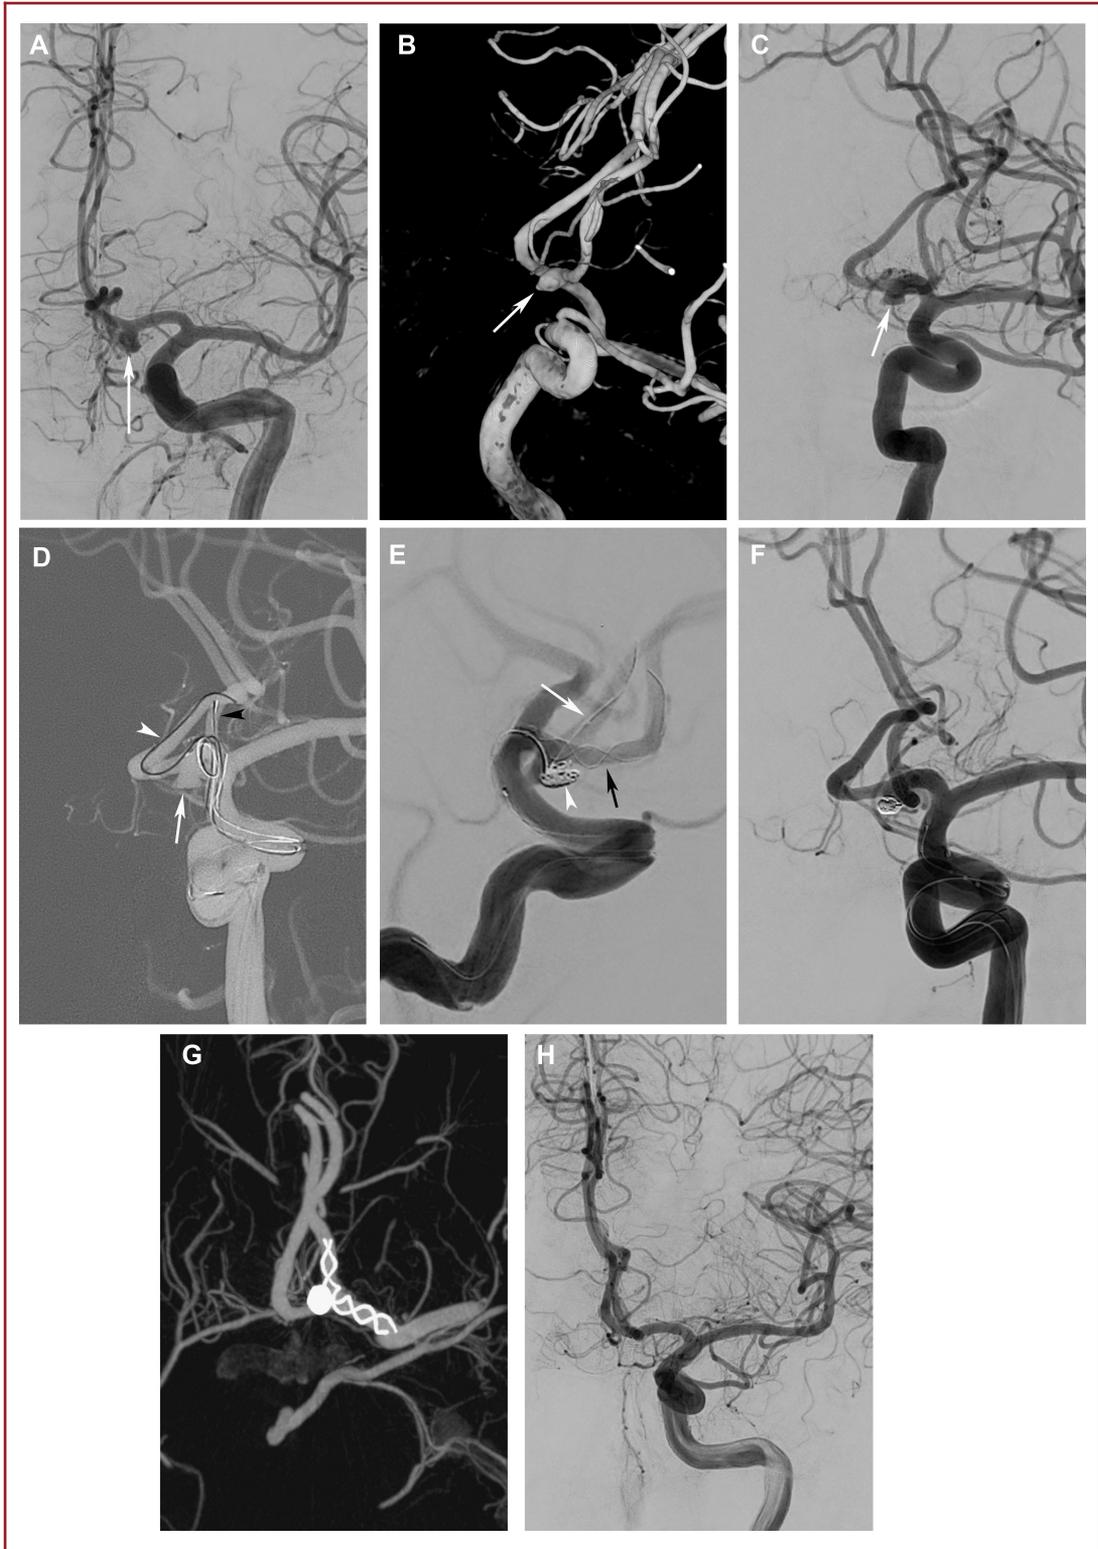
Intraoperative and follow-up angiography images of a 52-yr-old male patient with an AComA aneurysm. A-C, Preprocedural DSA and 3-dimensionally (3D) reconstructed flat-panel computed tomography (CT) images show a 4-mm AComA aneurysm. The A2 segments of both anterior cerebral arteries arise from the neck of the aneurysm. D, The intraoperative roadmap image shows the catheterization of anterior cerebral arteries with a double-lumen balloon catheter (white arrowhead) and a stent delivery microcatheter (black arrowhead). The aneurysm sac is located on the AComA (white arrow). E, The intraoperative DSA image demonstrates the coiling procedure (arrowhead) while the side branches are protected with a partially deployed braided stent (black arrow) and a balloon catheter (white arrow). F and G, The immediate postprocedural control DSA and maximum intensity projection reconstructed flat-panel CT images show complete occlusion of the coiled aneurysm sac (RRC 1). H, 18-mo follow-up DSA image shows the stable occlusion of the aneurysm.
